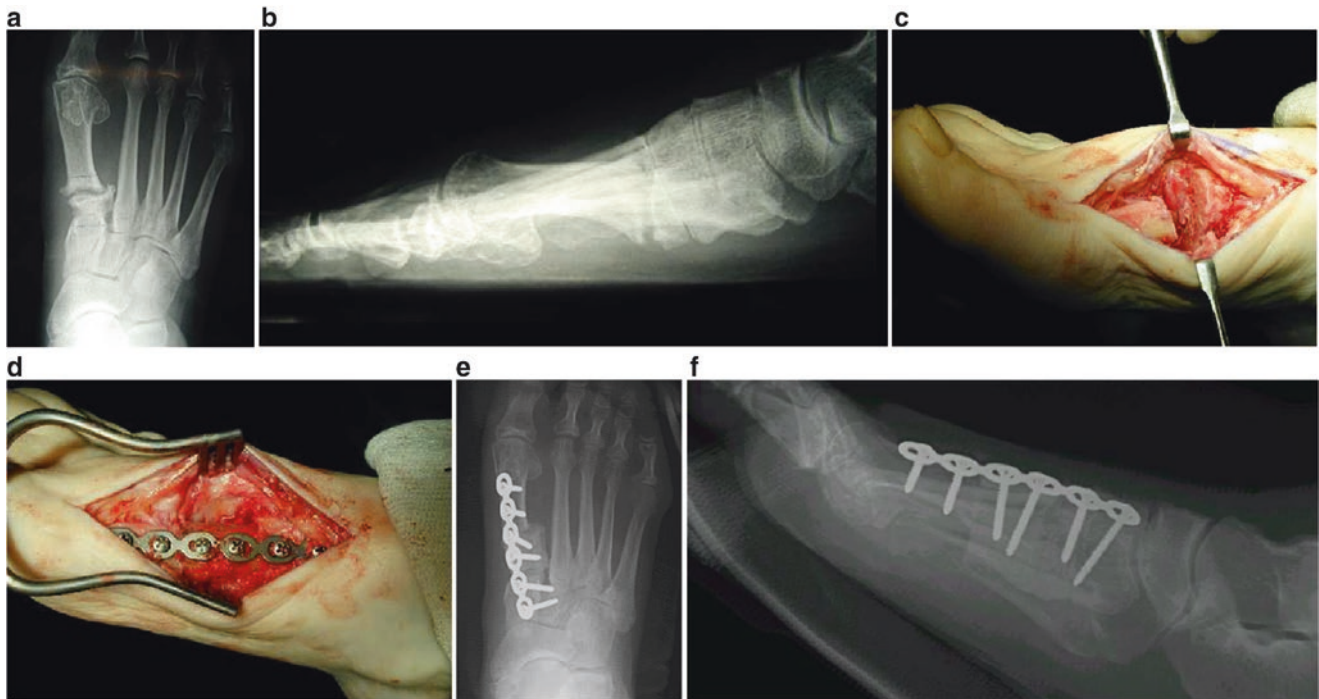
(a) AP radiograph showing nonunion following a first metatarsal base osteotomy for hallux valgus reconstruction resulting in severe shortening. (b) Lateral radiograph demonstrating significant first ray elevation. (c) Skeletal deficit following resection of the nonunion.
